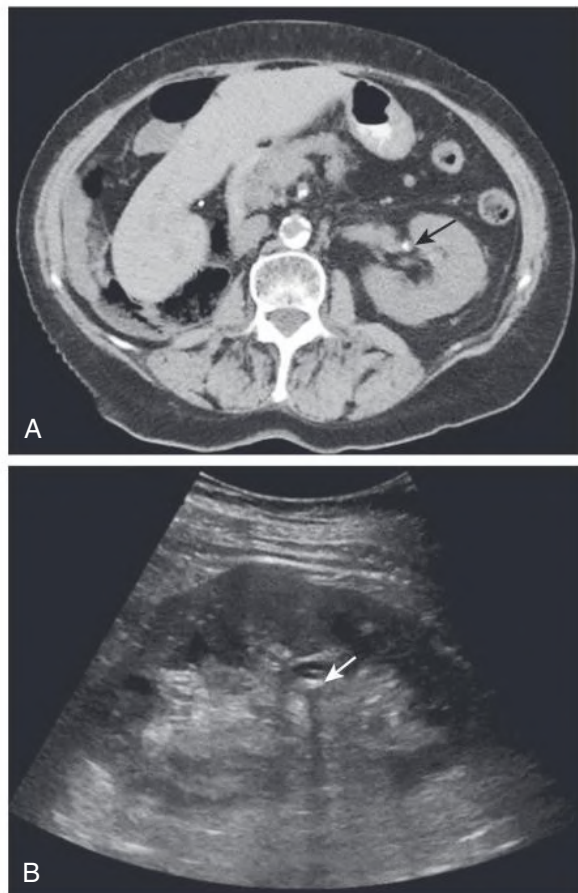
Kidney Calculi. (A) Unenhanced computed tomography scan showing a nonobstructing left kidney stone (*arrow*) in a patient with right nephrectomy. (B) Ultrasound of the left kidney (sagittal view) from the same patient showing a stone with an acoustic shadow behind it (*arrow*).
